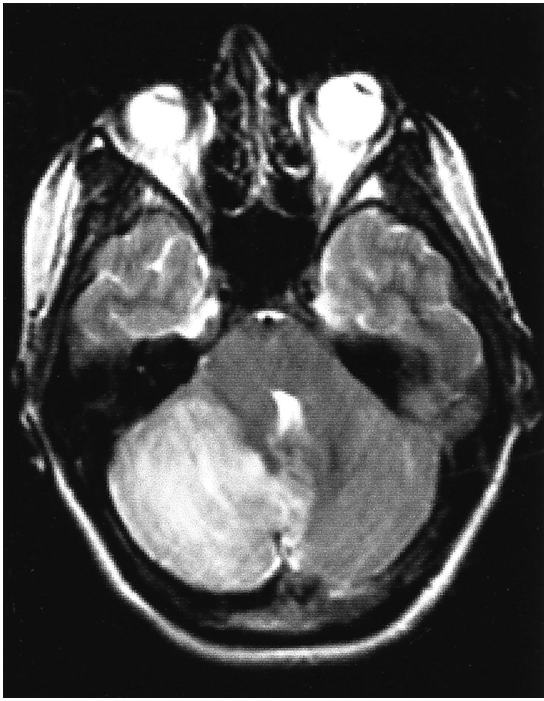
Case 2: T2-weighted brain MRI. Right cerebellar, hyperintense, pseudo-tumoral lesion producing mass effect on the fourth ventricle.
